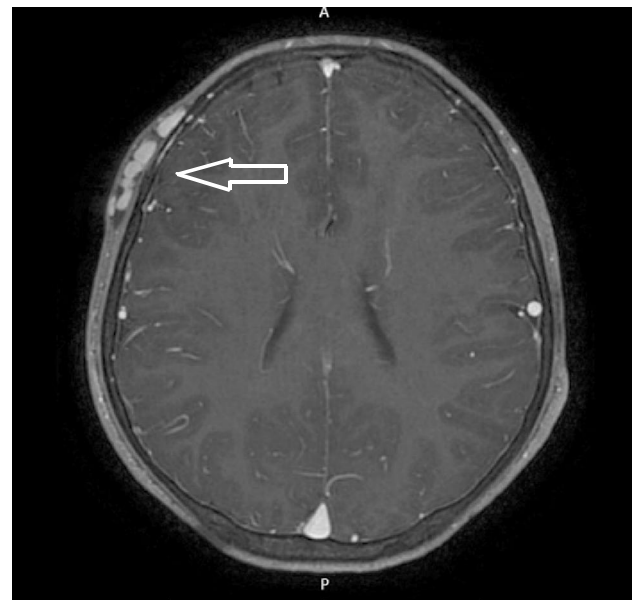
Axial post-contrast T1-weighted MRI (3T) image showing dilated venous channels (arrow in the picture) in right fronto-parietal region
